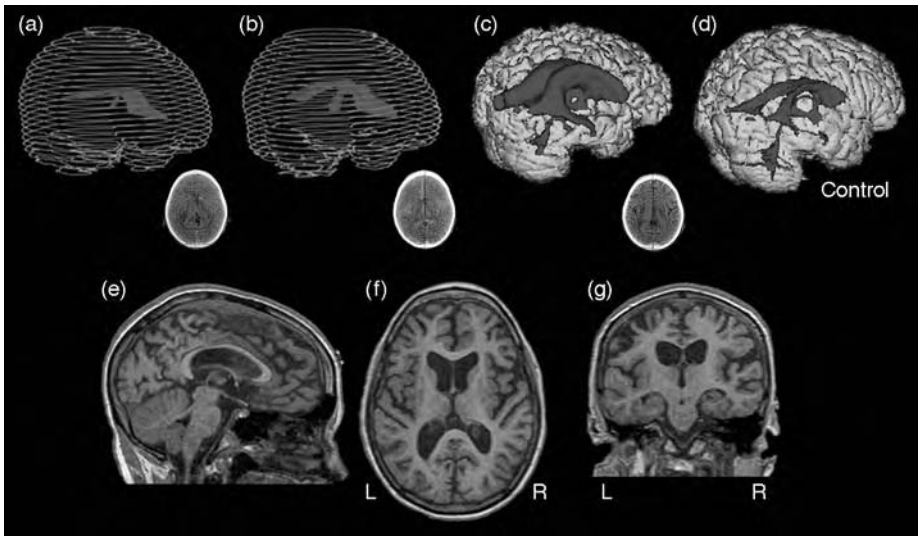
The top row depicts right posterior oblique views of the ventricular system following anoxic brain injury (ABI). (a) Day-of-injury computerized tomography (DOI CT) scan, (b) 6 days after injury, and (c) 18 months post-injury. Note the temporal horns can not be identified in a and b, presumably from generalized brain swelling that selectively compresses the temporal extension of the ventricular system. (d) A 3-D image of an age-matched control depicting normal ventricular systems. The bottom row depicts generalized atrophy in sagittal (e), axial (f), and coronal (g) planes in the follow-up magnetic resonance imaging (MRI) at 18 months post-injury. (A colour version of this figure is given in the Plate section.)
